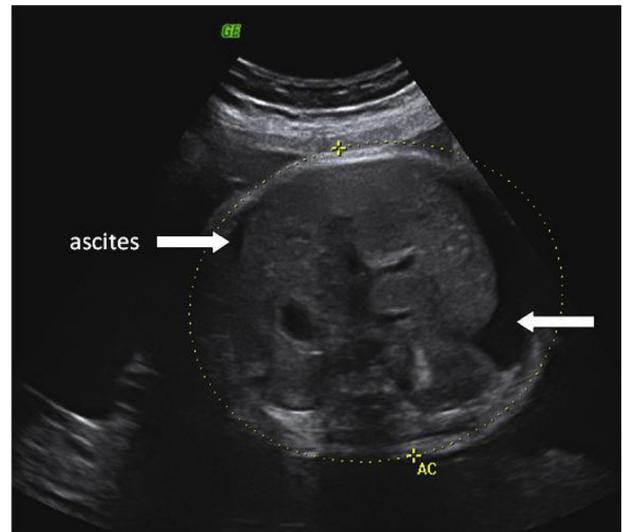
Prenatal ultrasound of Case 1 at 34 weeks of gestation shows fetal ascites.
